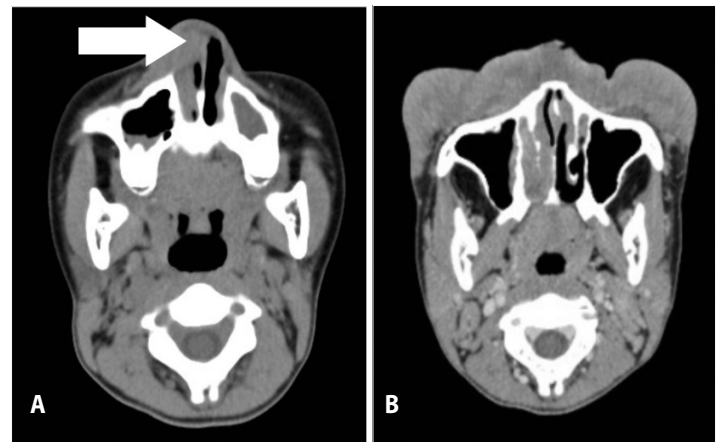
A. Paranasal sinus CT-scan with contrast in axial view (December 2013) showing a diffuse thickening of the soft tissue with heterogenous enhancement in the right nasal cavity (arrow). There is also a congested turbinate and bilateral maxillary sinusitis. B. Craniofacial CT scan with contrast (August 2014) showing a heterogeneously enhancing soft tissue thickening over the entire maxilla (white arrow) in axial view; and right inferior turbinate (white arrow) in C. coronal view; no bony lytic lesions were noted.
